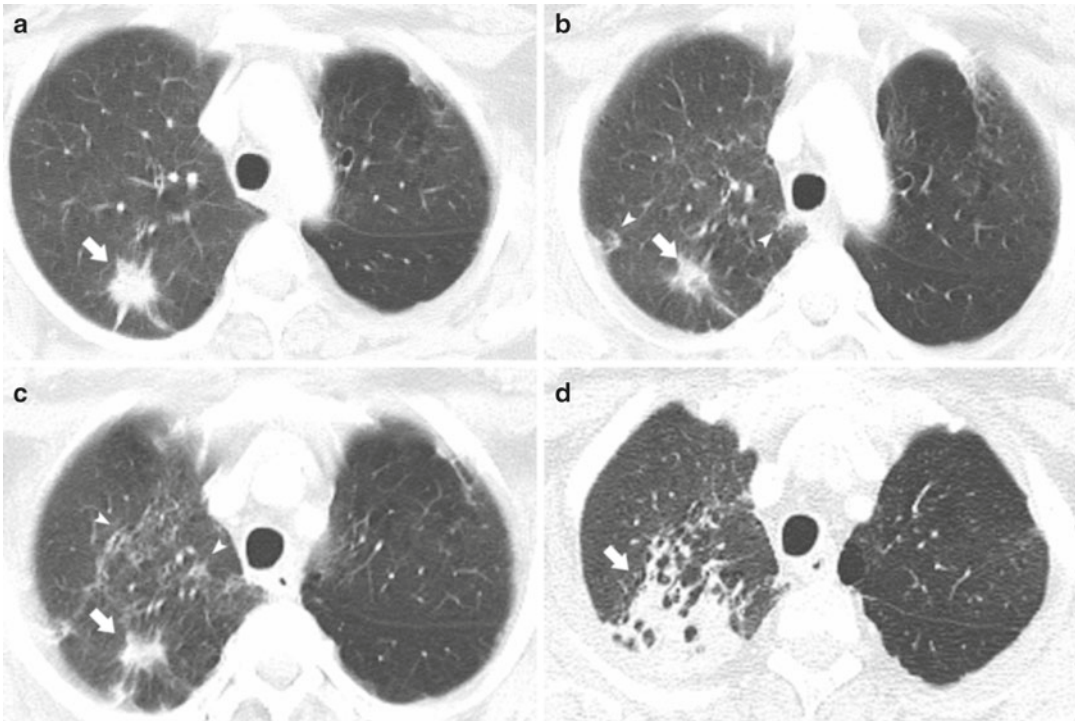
Progressive radiation injury following stereotactic body radiation therapy (SBRT) for lung carcinoma. (a) Pretreatment CT scan shows spiculated right upper lobe nodule (*arrow*). (b) CT scan image 1 month following radiation therapy shows decrease in size of the right upper lobe nodule (*arrow*). Mild patchy lung consolidation
